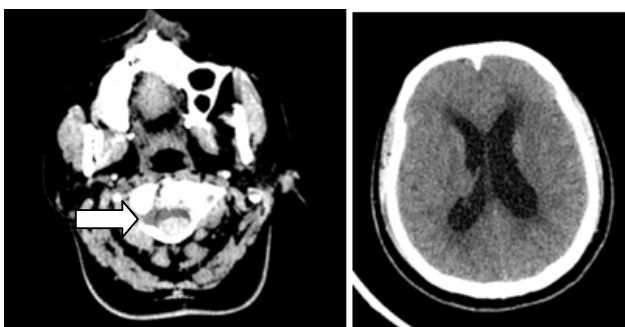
Magnetic resonance imaging - Axial non-contrast CT image at the level of upper cervical spine shows focal edema, with extension of lesion into spinal canal and Axial non-contrast CT image at the level of lateral ventricles shows moderate dilatation of the supratentorial ventricular system with minimal transependymal seepage.
